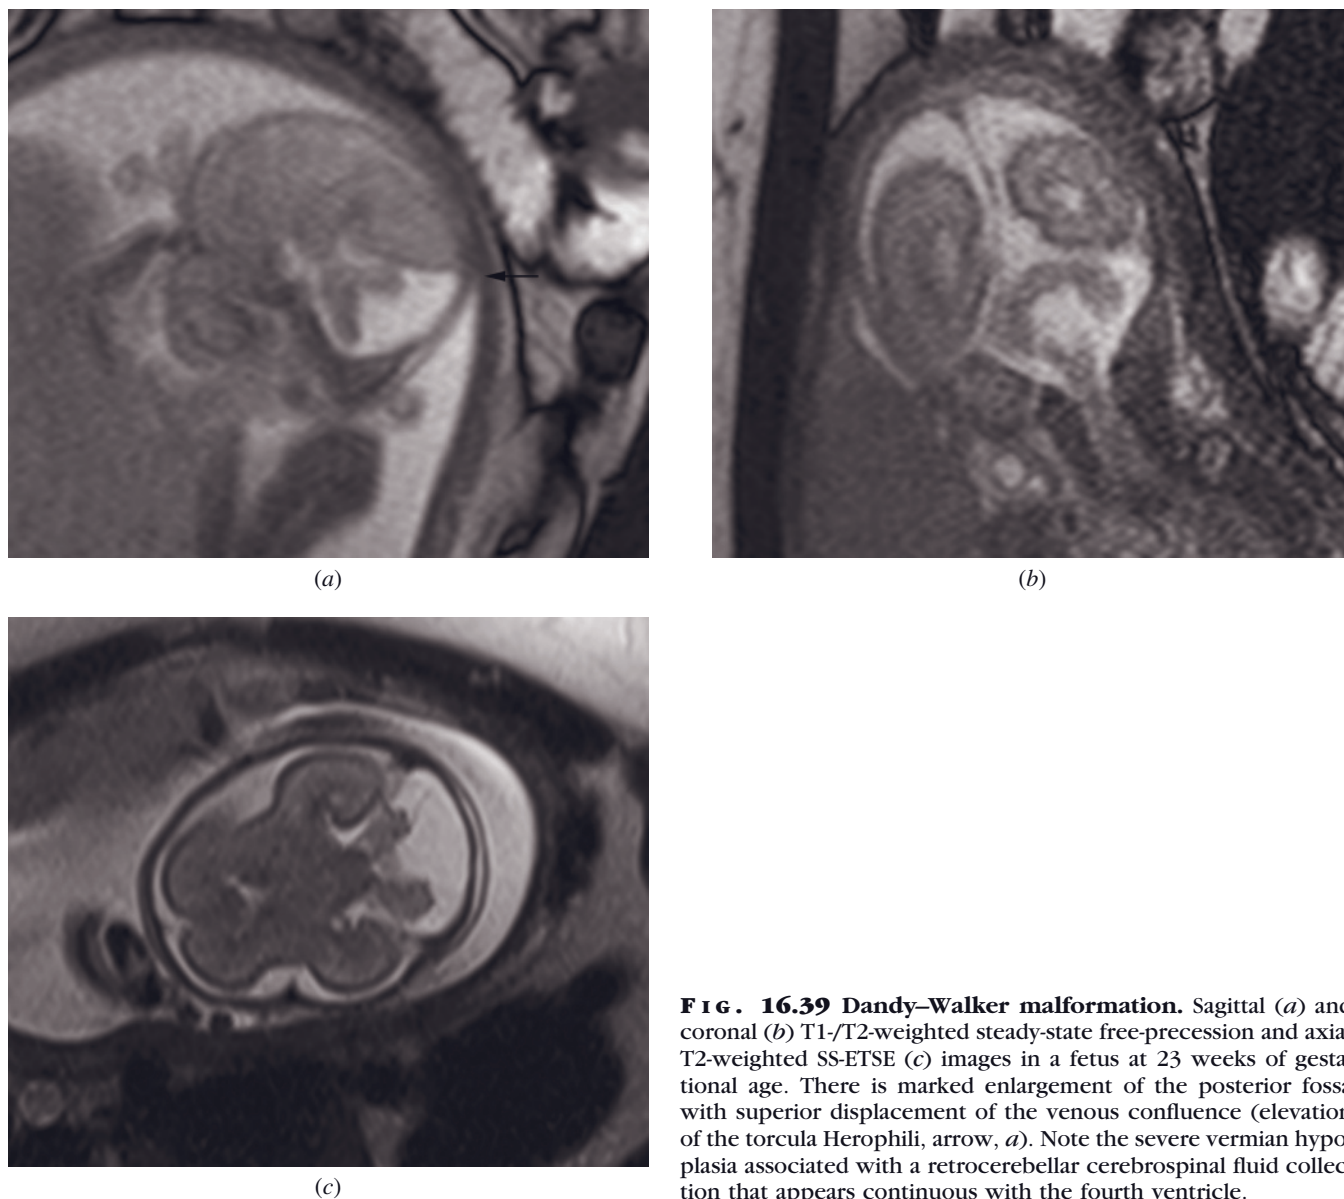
Dandy–Walker malformation. Sagittal (a) and coronal (b) T1/T2-weighted steady-state free-precession and axial T2-weighted SS-ETSE (c) images in a fetus at 23 weeks of gestational age. There is marked enlargement of the posterior fossa with superior displacement of the venous confluence (elevation of the torcula Herophili, arrow, a). Note the severe vermian hypoplasia associated with a retrocerebellar cerebrospinal fluid collection that appears continuous with the fourth ventricle.
